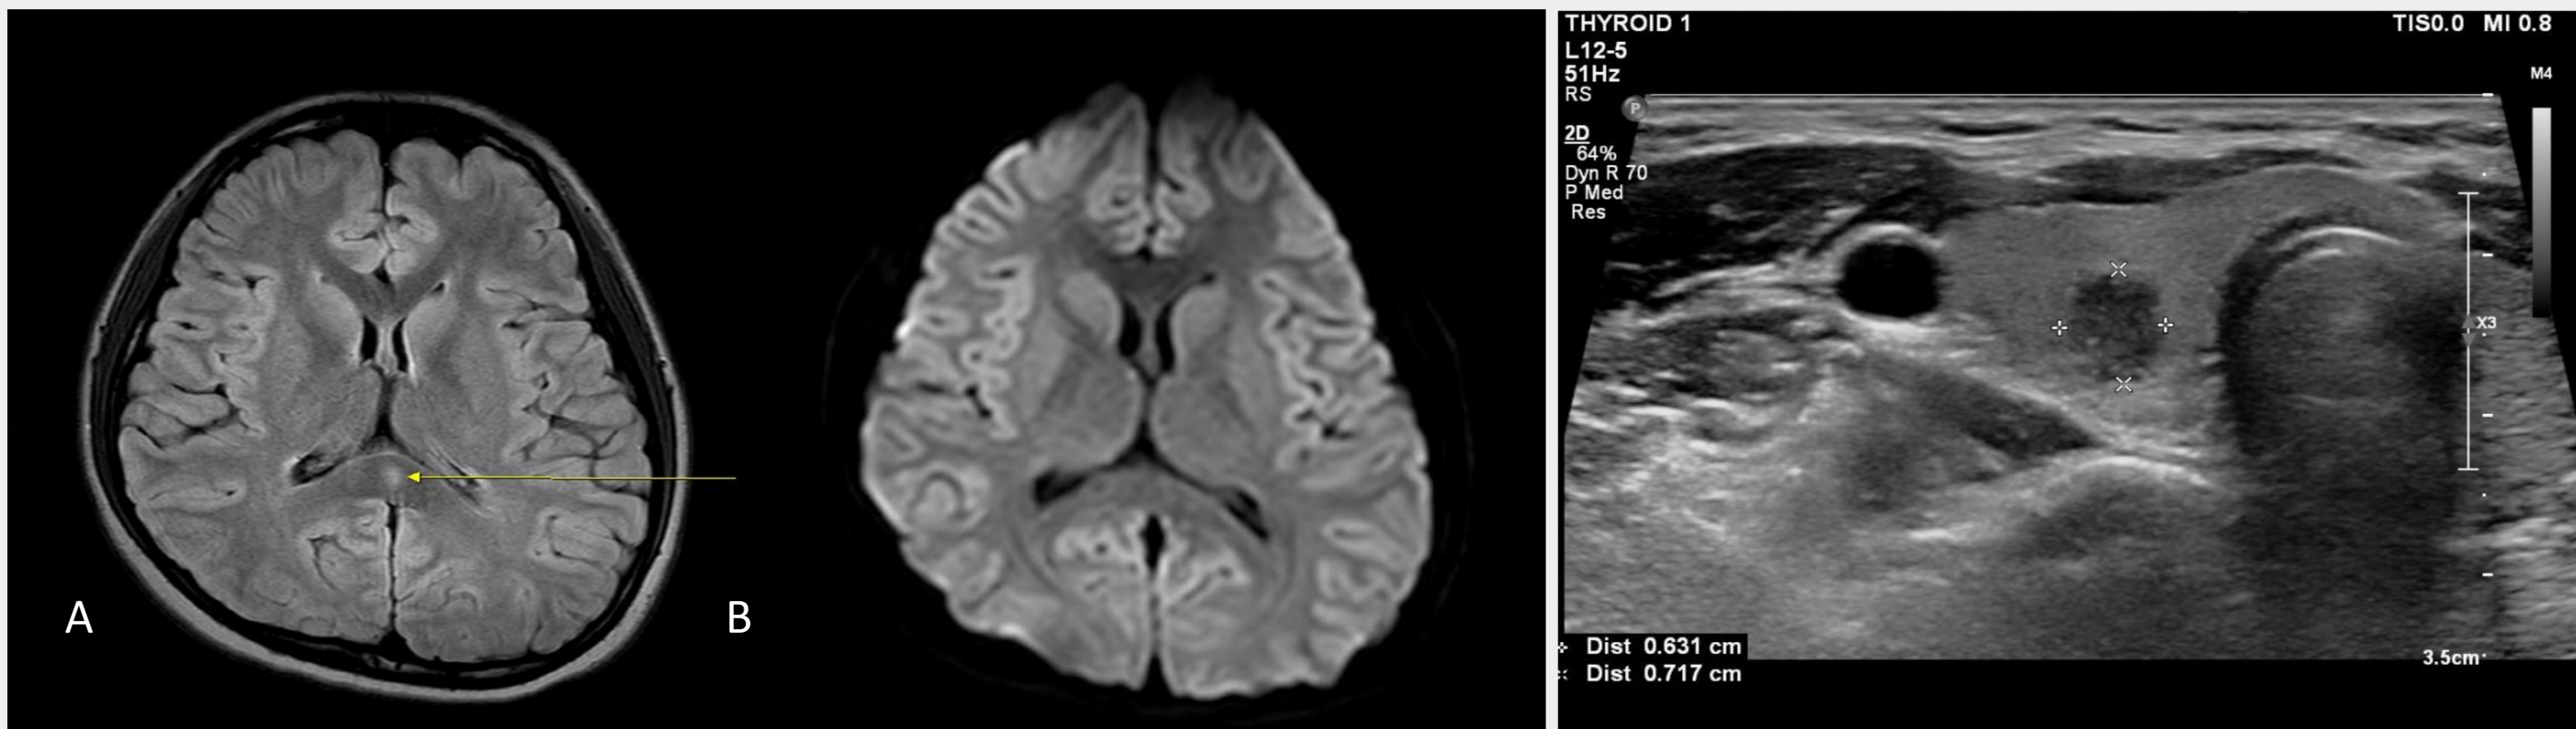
Brain MR images, (A) 2020-11-18, A small oval diffusion restriction lesion in the midline of corpus callosum splenium, (B) 2021-09-01, Disappear previously noted lesion
